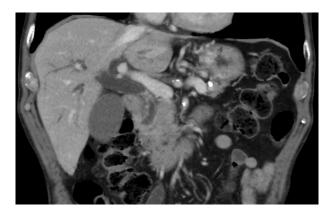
CT image showing a stricture in the mid common bile duct.
